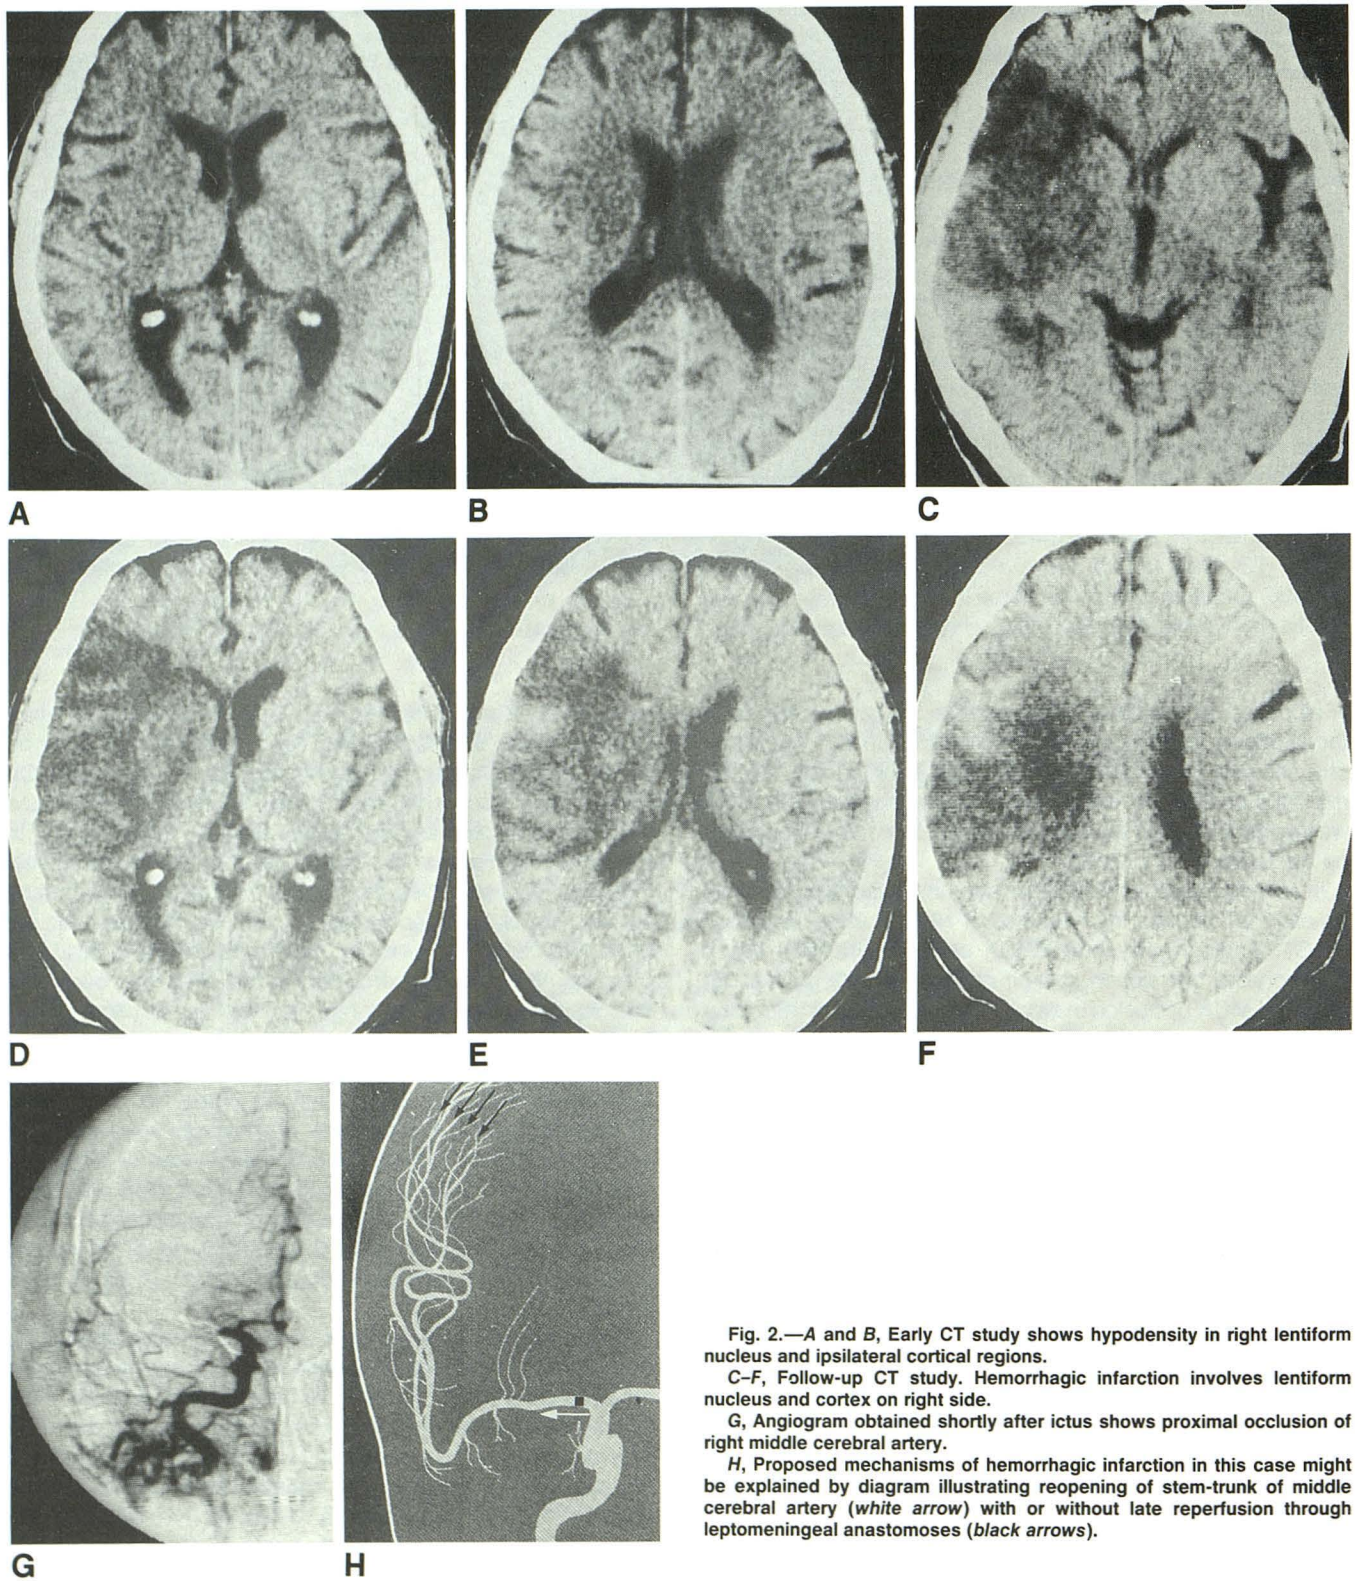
A and B, Early CT study shows hypodensity in right lentiform nucleus and ipsilateral cortical regions.
